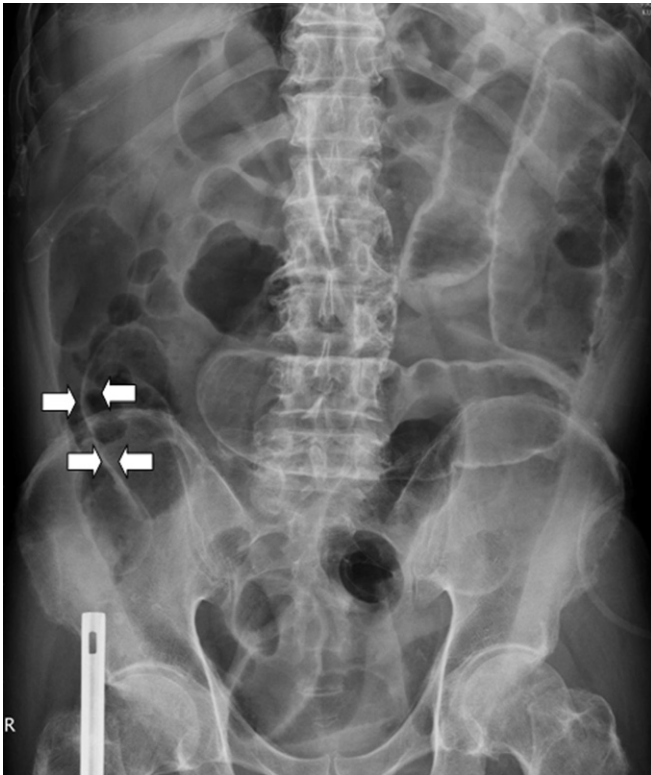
Radiographs showed Rigler's sign (arrows), i.e., visibility of the bowel wall when it is outlined by intraluminal and extraluminal air.
